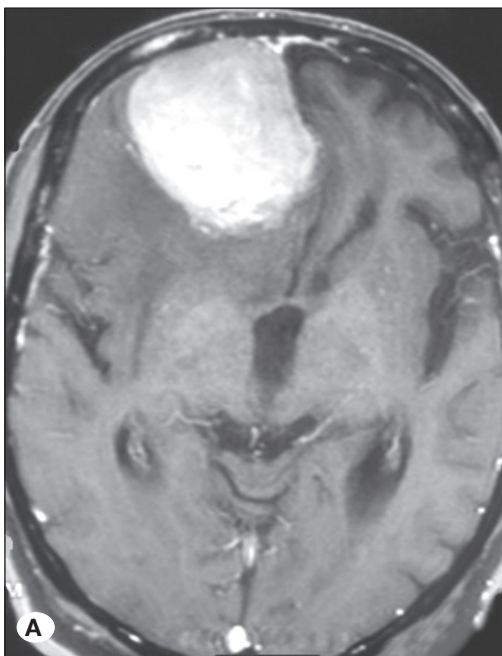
An MRI from “Case 3” revealing a right frontal mass with homogeneous contrast enhancement and measuring 5.3×4.8×7.1 cm. The mass extended into the lamina cribrosa and olfactory groove; A) axial T1W and B) coronal T1W sequences.
